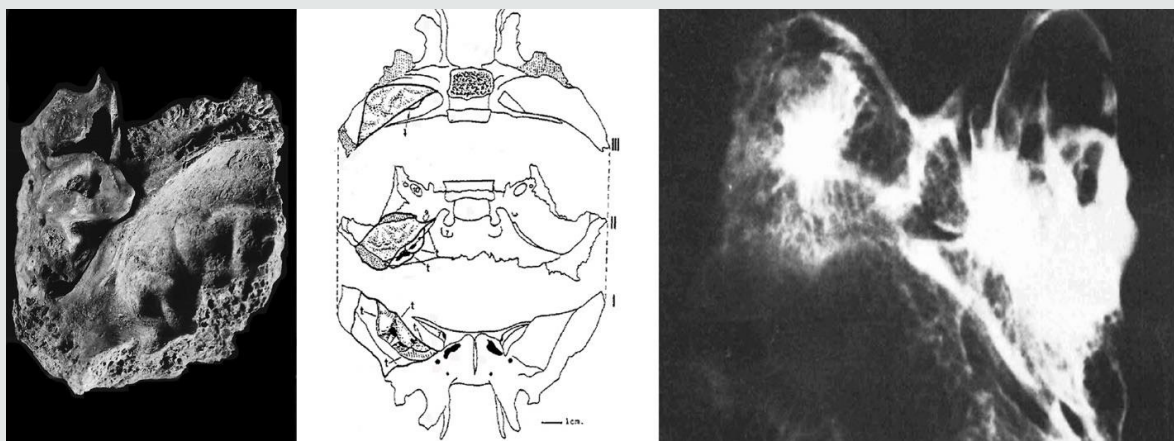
Left. Sidelong anterior photo of the greater wing of the sphenoids of Clunia 7, which shows the orbital and external surfaces. Centre. Location of pathological fragment in the sphenoids. Right. X-ray of the piece, which shows the intra-tumorous cavities, the vascular tubes and the thickened zone.
